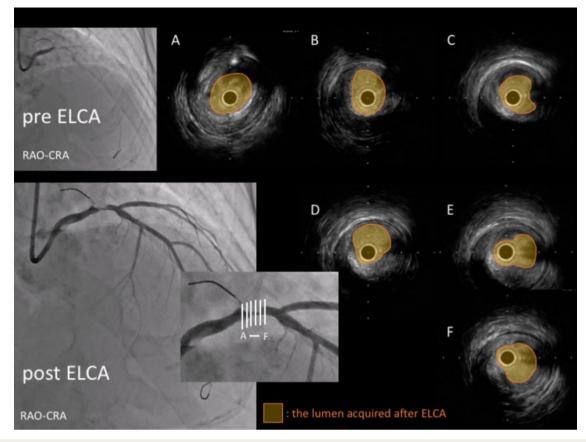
Intravascular ultrasound imaging acquired after excimer laser coronary angioplasty in case 1. Intravascular ultrasound revealed debulking of the plaque burden and thrombus by excimer laser coronary angioplasty. CAU, caudal view; CRA, cranial view; ELCA, excimer laser coronary angioplasty; IVUS, intravascular ultrasound; KBT, kissing balloon technique; LAD, left anterior descending artery; LAO, left anterior oblique; LMCA, left main coronary artery; AO, right anterior oblique; TIMI, thrombolysis in myocardial infarction.
